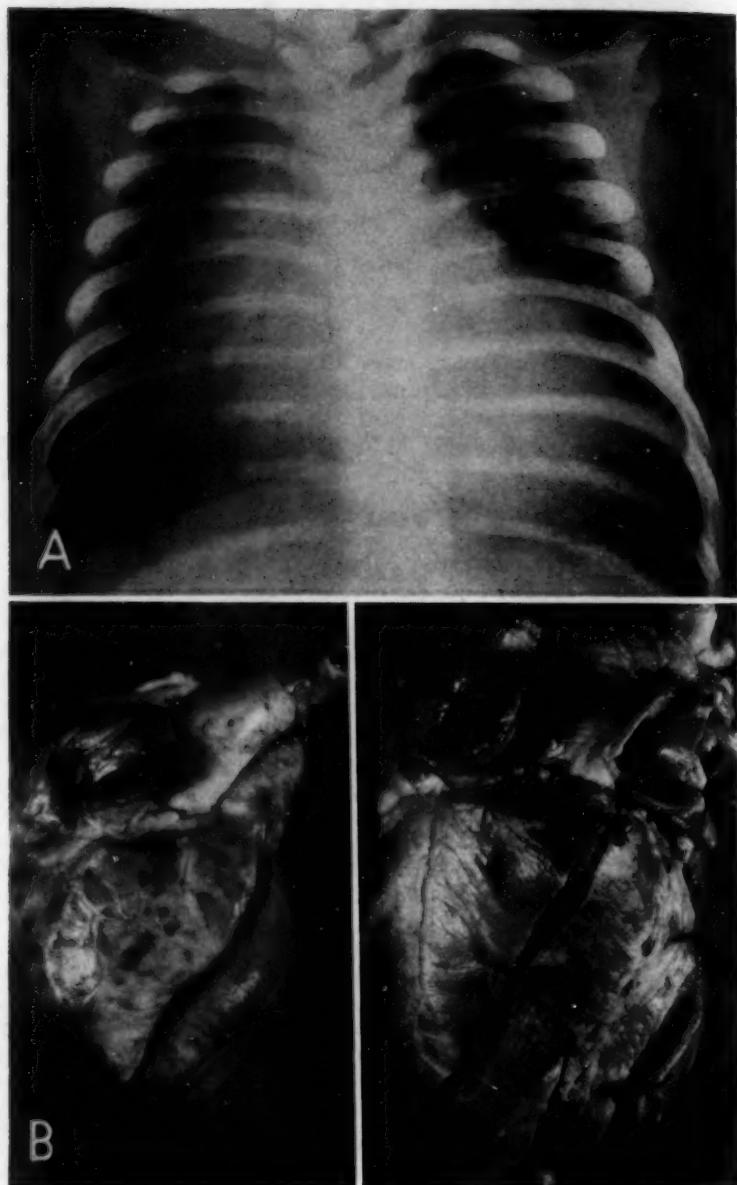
(case 1).—*A*, roentgenogram taken a few hours before death. *B*, heart (right) of the patient in comparison with a normal heart (left) from an infant of the same age.
